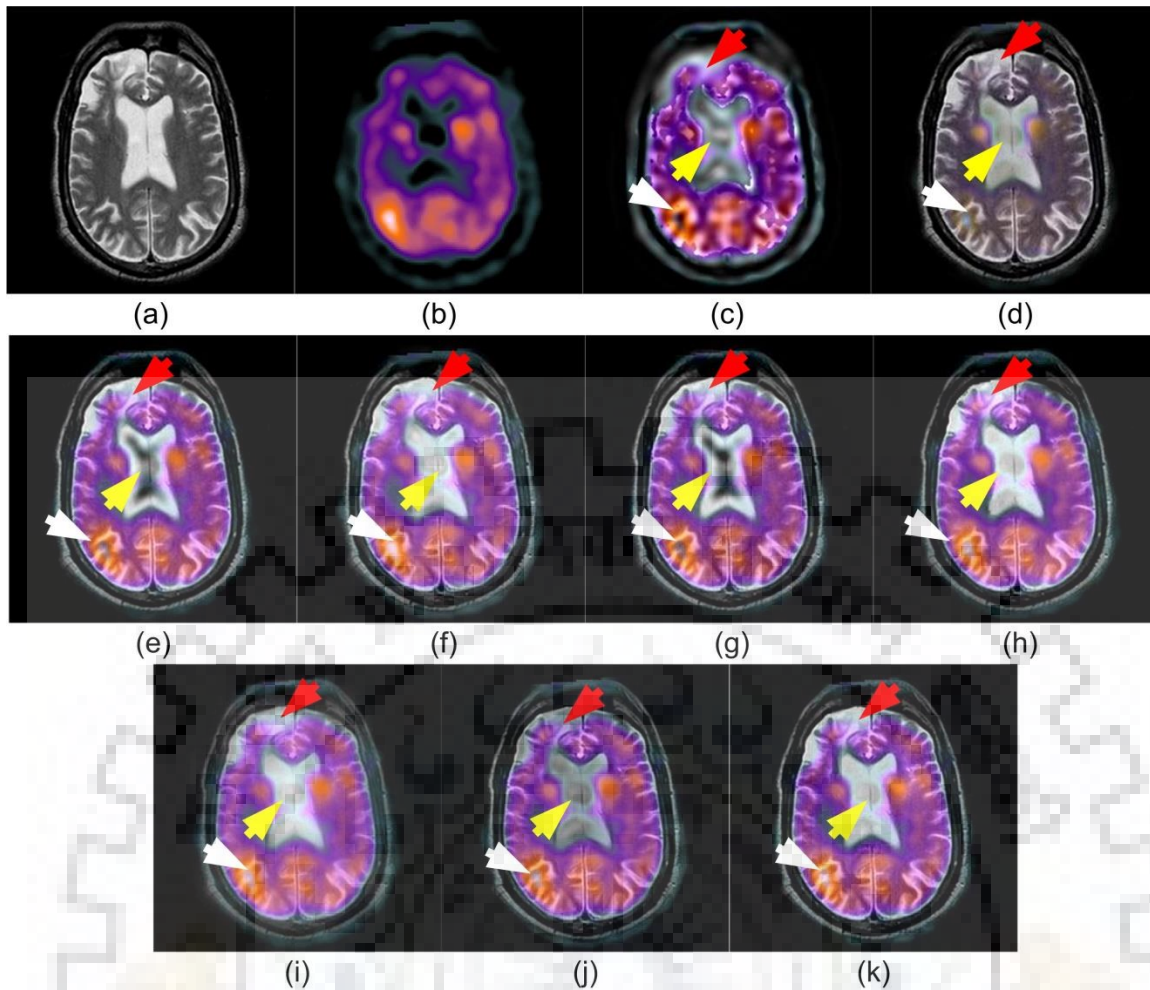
Input image pair-2 (a) MR image (b) SPECT image, qualitative comparisons of fused images obtained by (c) Bhatnagar et al., 2013 [18] (d) Li et al. 2013 [94] (e) Yang et al., 2015 [200] (f) Yang et al. 2016 [201] (g) Yang et al., 2017 [203] (h) Liu et al., 2017 [111] (i) Hermessi et al., 2018 [57] (j) Hou et al., 2019 [59] (k) Proposed CNN-MIF
